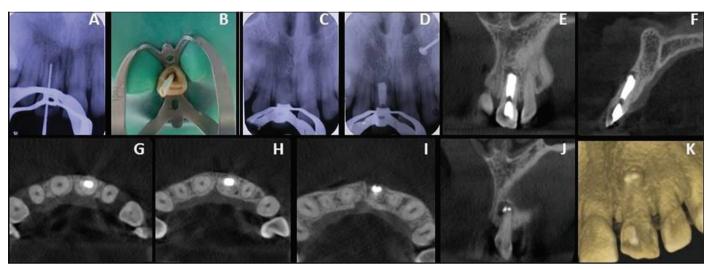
(a) IOPA radiograph showing working length determination. (b) Placement of calcium hydroxide in the canal with absorbent paper point. (c) IOPA radiograph showing increase in the radiopacity of the root canal space following calcium hydroxide placement in left central incisor. (d) IOPA radiograph showing obturation with mineral trioxide aggregate (MTA). (e) Post-operative CBCT image in coronal plane showing MTA obturation. (f) Post-operative CBCT image in sagittal plane showing MTA obturation. (g) Post-operative CBCT image in axial plane at coronal third of root showing MTA obturation. (h) Post-operative CBCT image in axial plane at apical third of root showing MTA obturation. (i) Post-operative CBCT image in axial plane at apical third of root showing MTA obturation. (j) Post-operative CBCT image in axial plane at apical third of root showing MTA obturation. (j) Post-operative CBCT image in coronal plane showing MTA obturation. (i) Post-operative CBCT image in axial plane at middle third of root showing MTA obturation. (i) Post-operative CBCT image in axial plane at apical third of root showing MTA obturation. (j) Post-operative CBCT image in coronal plane showing slight extrusion of MTA into the lesional space. (k) 3D CBCT image immediately after MTA obturation showing MTA extrusion into the lesional space.
